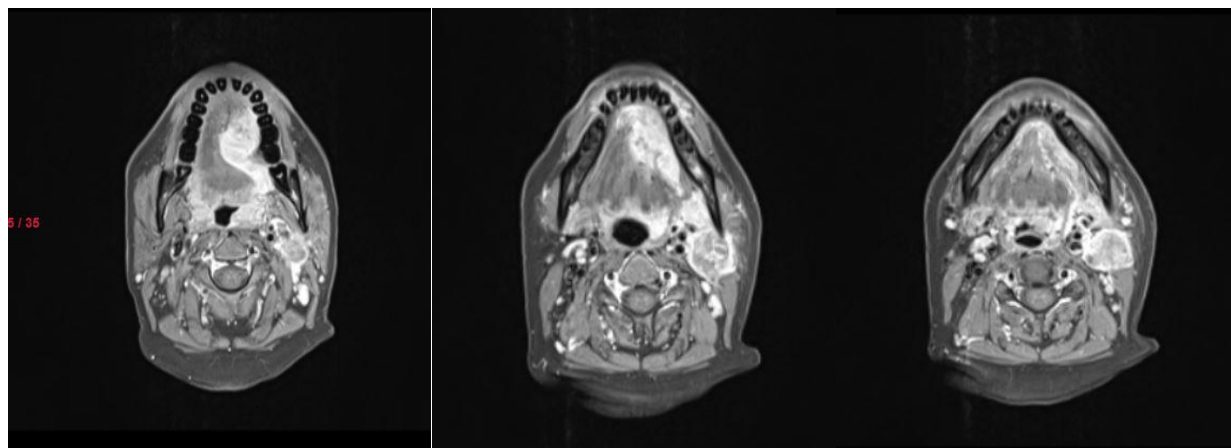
/4/5: Show MRI images of a patient with bleeding Ca Tongue. Heterogeneously enhancing lesion involving left side of tongue crossing midline and almost reaching Vallecula on left side. Also seen is bulky left Level II Cervical Lymph node.
